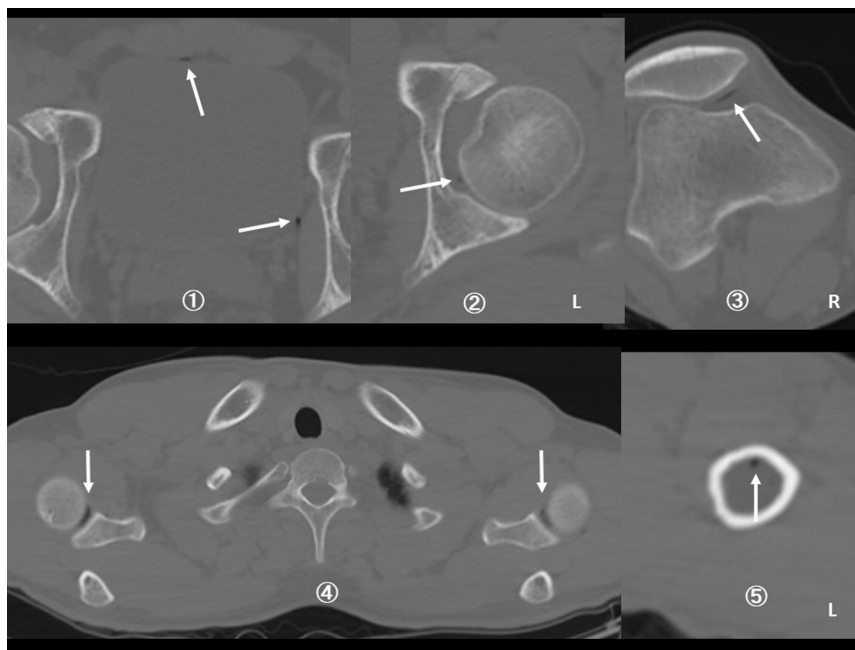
Whole-body computed tomography (CT) findings on arrival. CT shows air density around the bladder (1), left hip (2), right knee (3), bilateral shoulder (4) joints, and right intramedullary humerus (5). There were no lung lesions.
